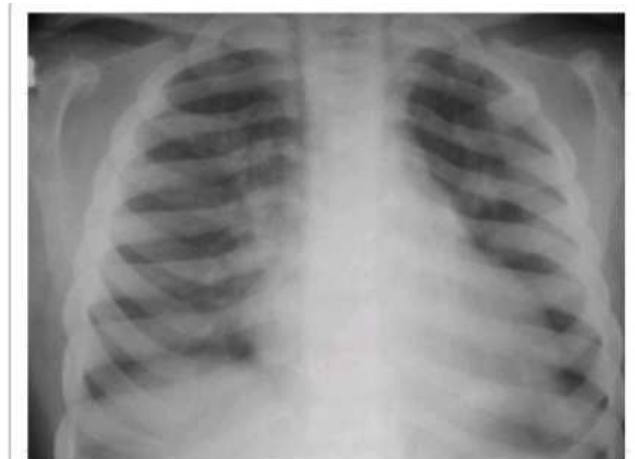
Anteroposterior chest x-ray showing paddle and spatulated ribs
